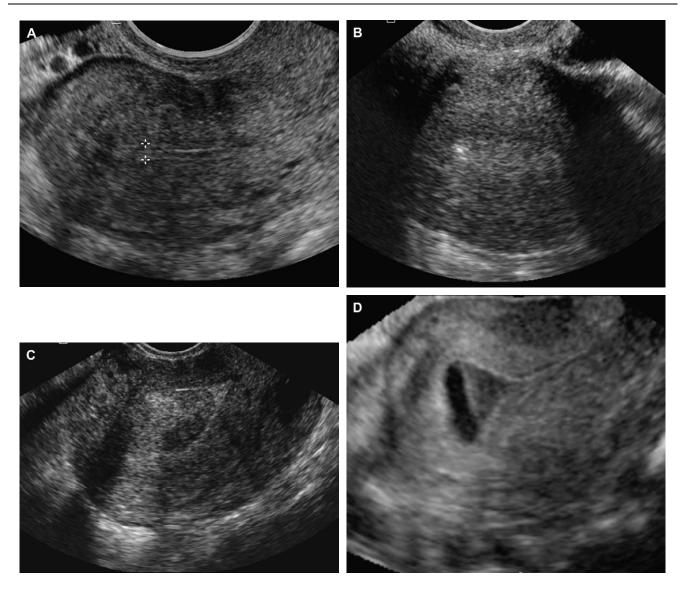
Classification of endometrial patterns on transvaginal ultrasound. A, Sagittal view of the uterus with an endometrial trilaminar pattern. B, Transverse view of a homogenous hyperechoic endometrial pattern. C, Sagittal view of a heterogeneous endometrial pattern. D, Sagittal view of a pseudogestational sac that contains fluid and debris.
